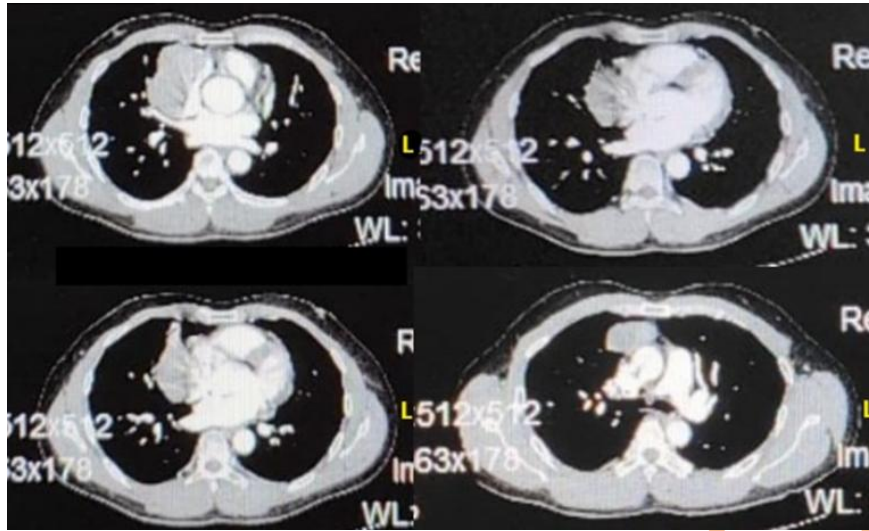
Patient's contrast-enhanced chest CT-scan result
